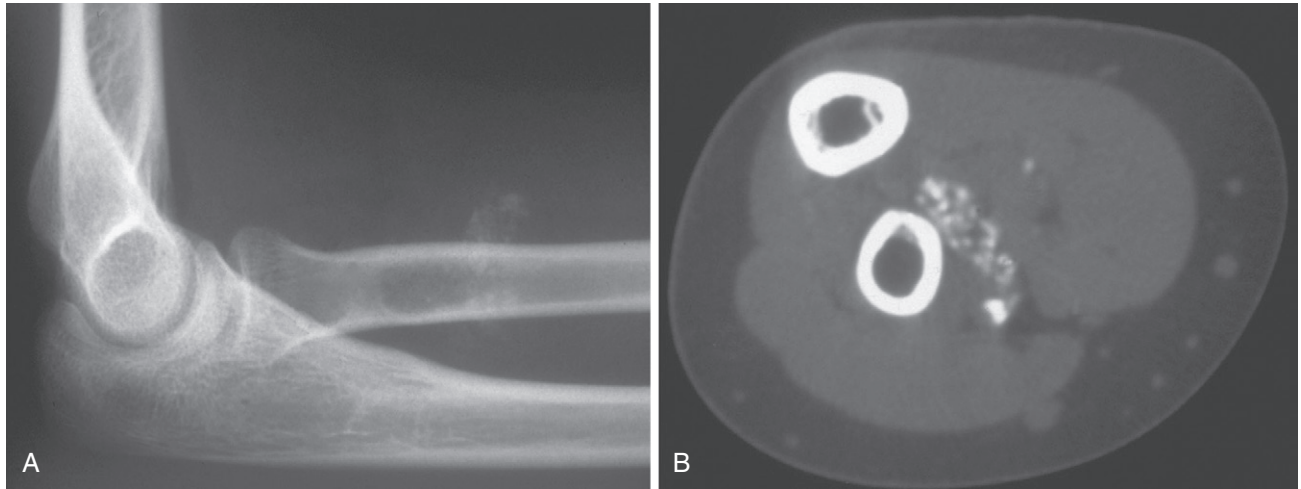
A, Focally mineralized synovial sarcoma in the deep soft tissues in the vicinity of the elbow joint. B, Axial computed tomography scan shows intratumoral calcification.
